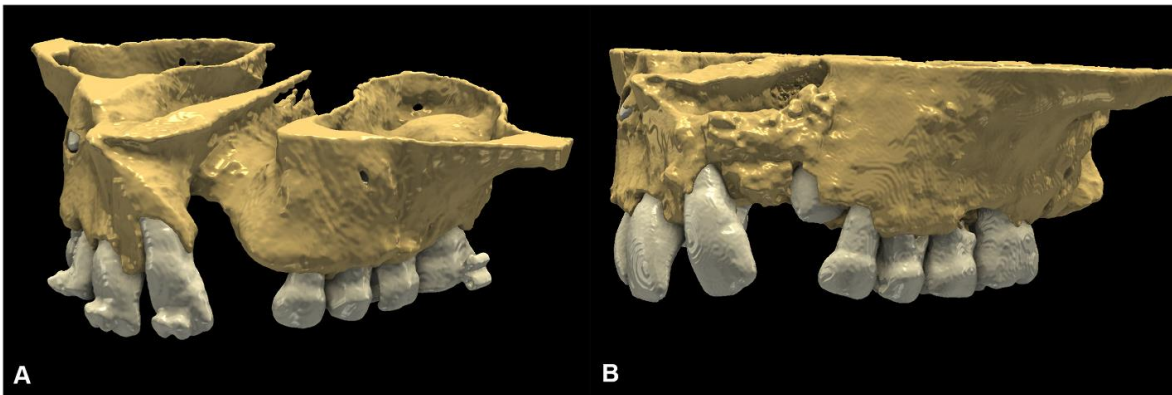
Segmented 3D models of CBCT datasets: (A) virtual model of baseline hard-tissue conditions; (B) virtual model of 3-month follow-up hard-tissue conditions.
